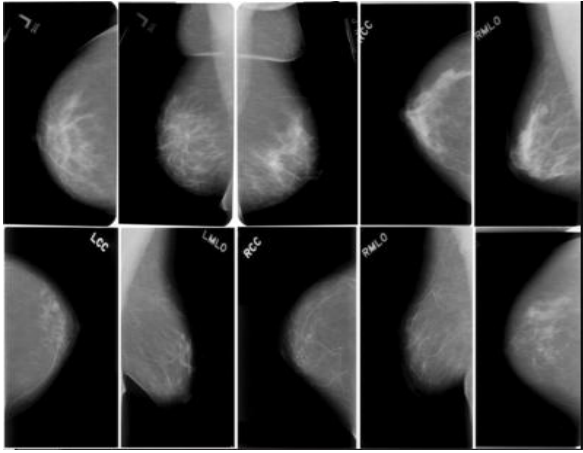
Multiview structural mammary radiograph set.
